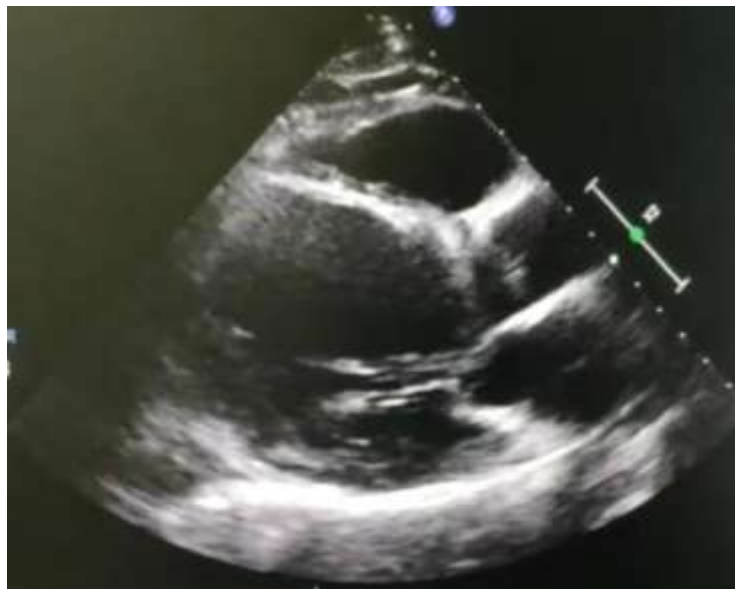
Dilatation of the left ventricle in long axis echocardiographic section.
